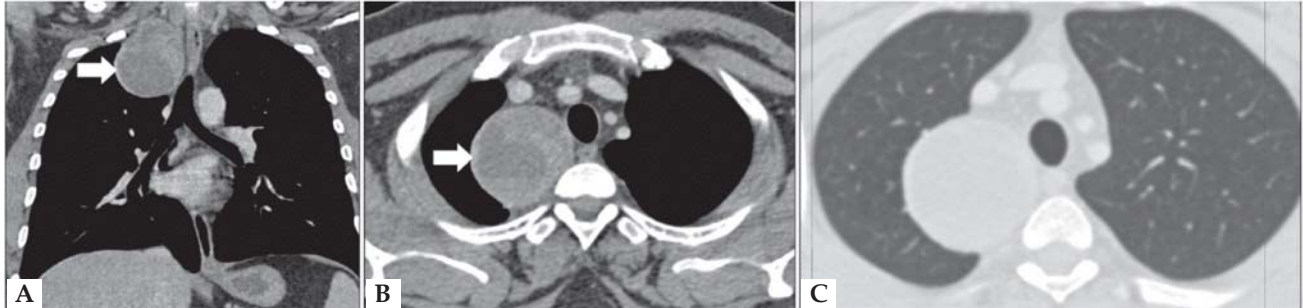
Contrast enhanced coronal reconstructed computed tomography image showing (A) a well-defined heterogeneously enhancing round soft tissue mass with internal necrosis (arrow) in superior mediastinum, (B) abutting the right lateral margin of trachea on the axial image and (C) on axial lung window image, no pulmonary parenchymal changes are seen in the surrounding region.
